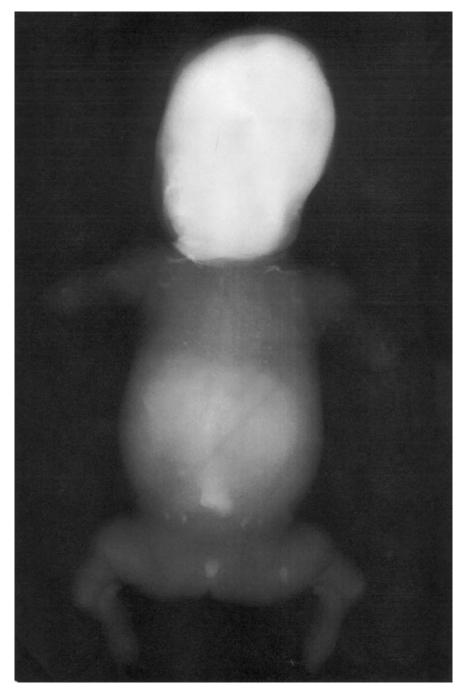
Radiographic features of hypophosphatasia. There is a striking lack of mineralization that can be detected radiographically.
